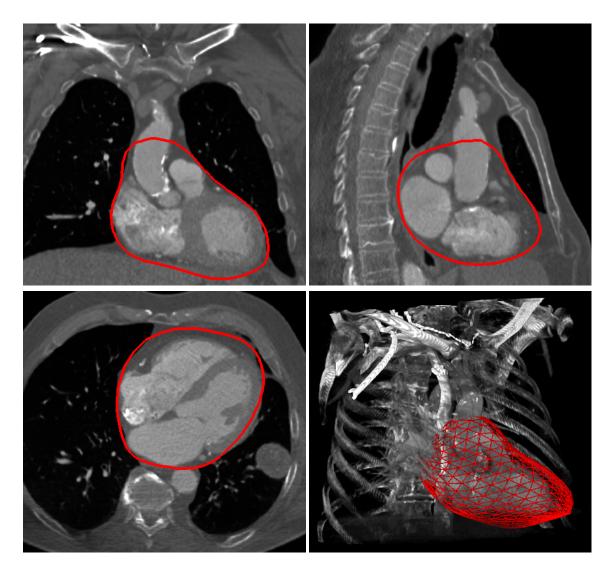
Slices of a volumetric CT scan of the human torso (\mathcal{M}) overlaid by the automatically segmented pericardium mesh A_{\mathcal{M}}, the intersection of A_{\mathcal{M}} with the plane corresponding to the visualized slice is shown in red color. Lower right: 3D rendered CT volume with 3D anatomical overlay (A_{\mathcal{M}}).
